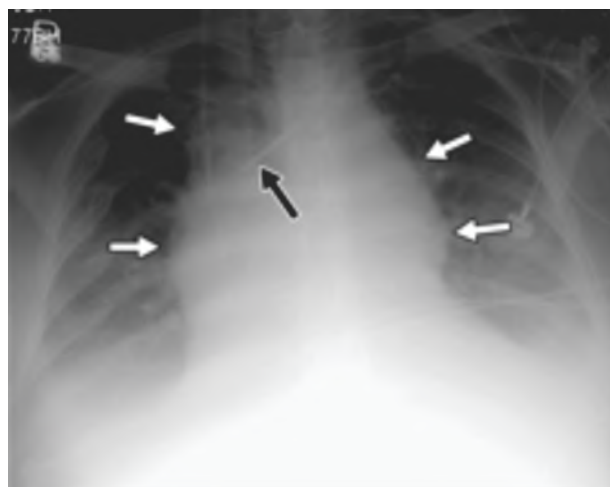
Frontal chest x-ray following placement of a central venous catheter shows right paratracheal soft tissue with a bulging contour (arrows), due to mediastinal hematoma.
